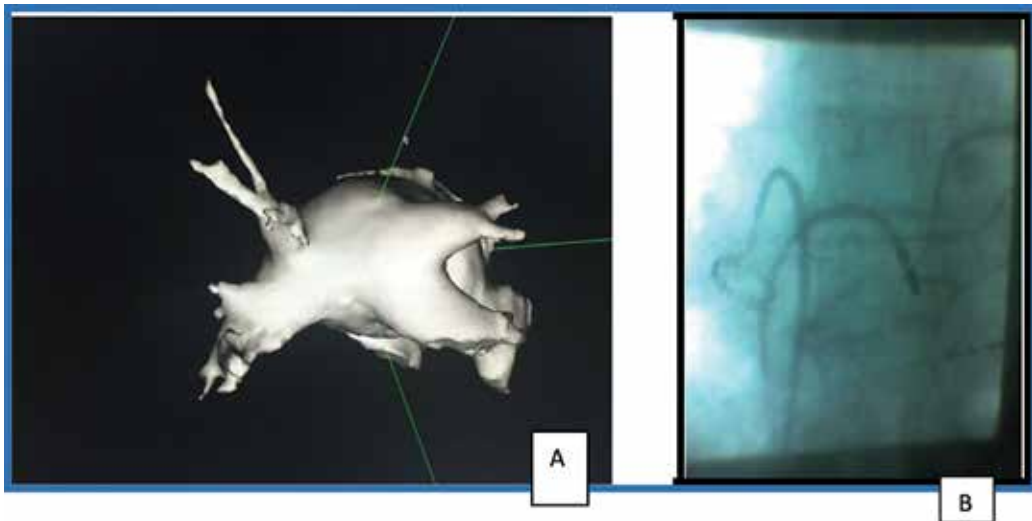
(A) Computed tomography with contrast shows four pulmonary veins: two on the left side and two on the right side and (B) X-ray during mapping of the right inferior pulmonary vein in the AP view. No PVPs were detected inside this vein.
